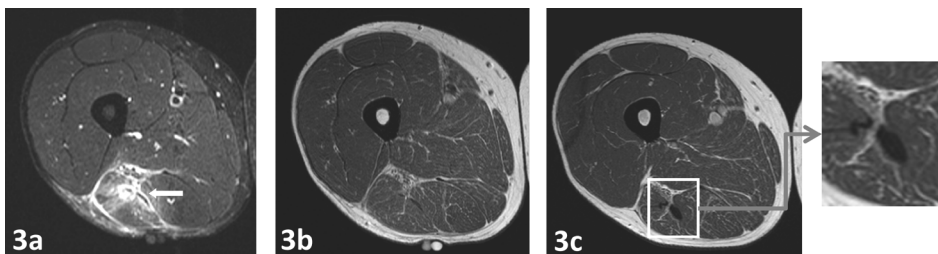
(A) Short-tau inversion recovery (STIR) image of the initial injury showing extensive increased signal intensity at the musculotendinous junction of the musculus biceps femoris (arrow). (B) T1-weighted image of the same initial injury showing no abnormality. (C) T1-weighted image at return to play showing an increased area of low-signal intensity at the site of the injury, indicating fibrous tissue formation.
